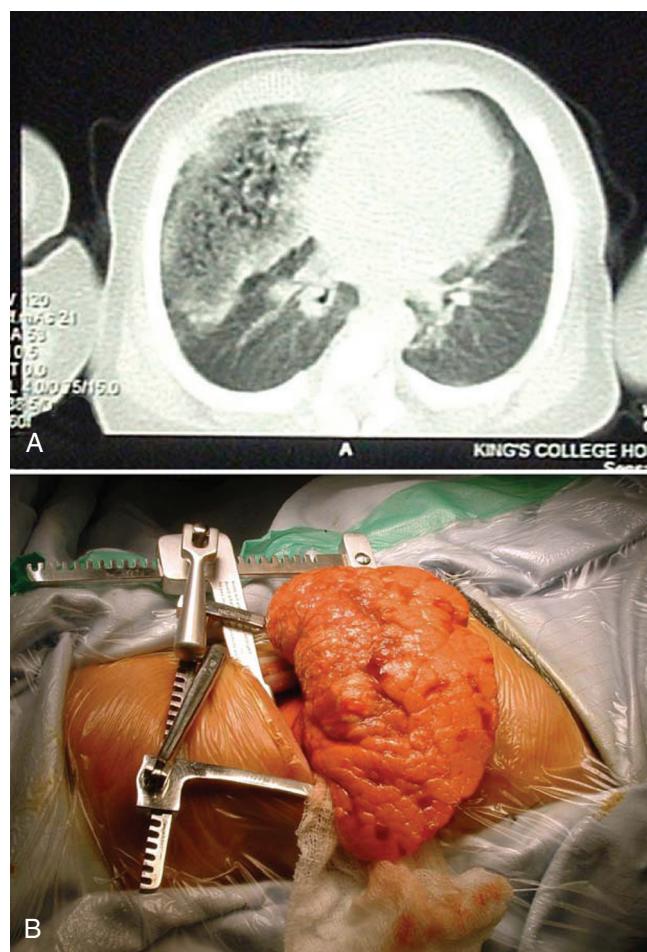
A, Computed tomography scan showing right-sided microcystic congenital pulmonary airway malformation (CPAM). B, Lung resection of predominantly solid and small cysts (type 2 CPAM). (Adapted from Stanton M, Davenport M. Management of congenital lung lesions. *Early Human Dev*. 2006;82:289, with permission.)
